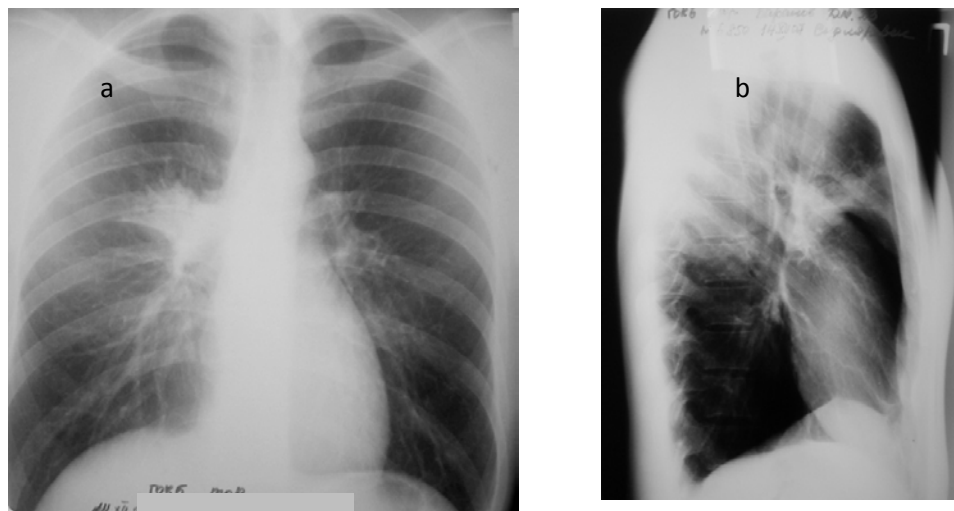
Survey radiographs of the 23-year-old patient's thorax in frontal (a) and right lateral (b) projections. The limited shadow in the forward (III) segment of the upper lobe of the right lung. Shadow has average intensity in the medial part and small intensity on the peripheries, its contours are indistinct, except for the bottom border adjoining the interlobe fissura. The hilum on the right is expanded. Acute right pneumonia with affection of the anterior segment of the upper lobe of the right lung by analogy with periscissuritis
